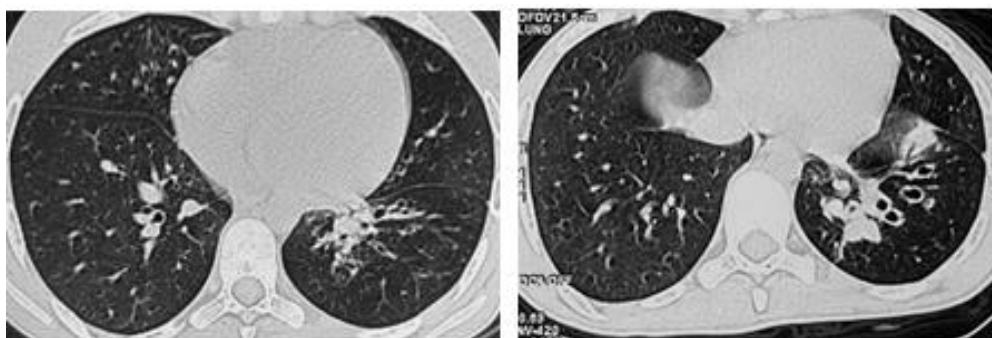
Chest CT scan showing diffuse bronchial dilations located in mucoid impactions with diffuse bronchial thickening.
